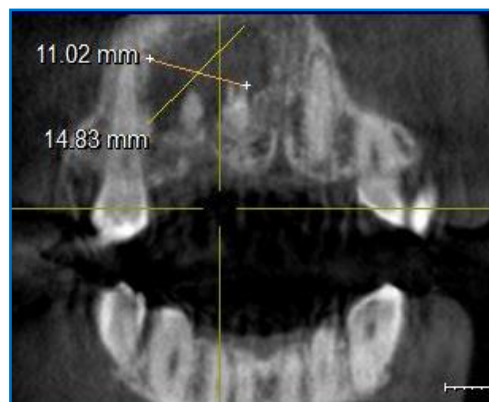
Preoperative CBCT in coronal slice
